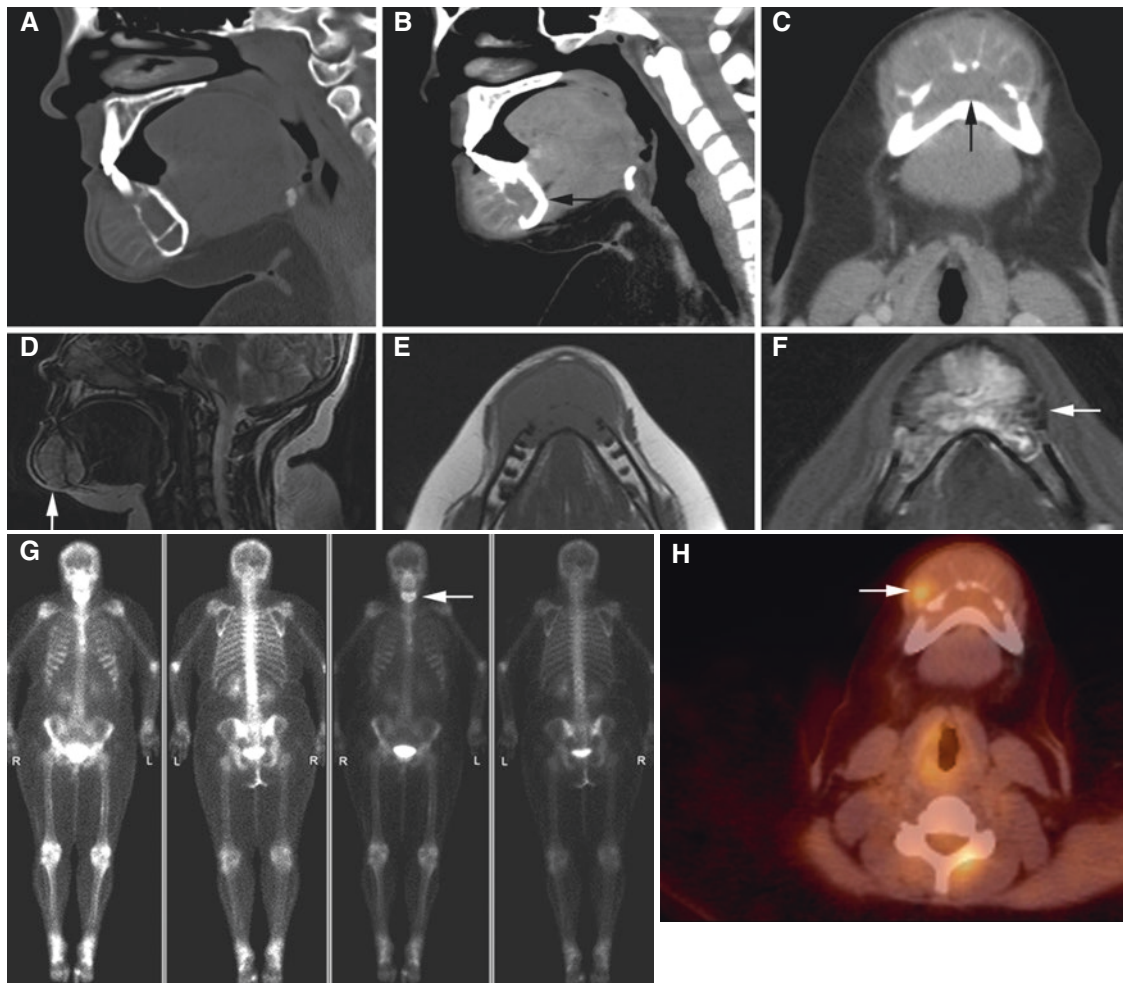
Ewing sarcoma, mandible; 17-year-old female with mass in anterior part of the mandible. (A) Sagittal (bone window), (B) sagittal (soft-tissue window), and (C) axial (soft-tissue window) CT images show soft-tissue mass, bone destruction, and radiating bone septa (sunburst appearance) (*arrow*). (D) Sagittal STIR MRI confirms radiating
